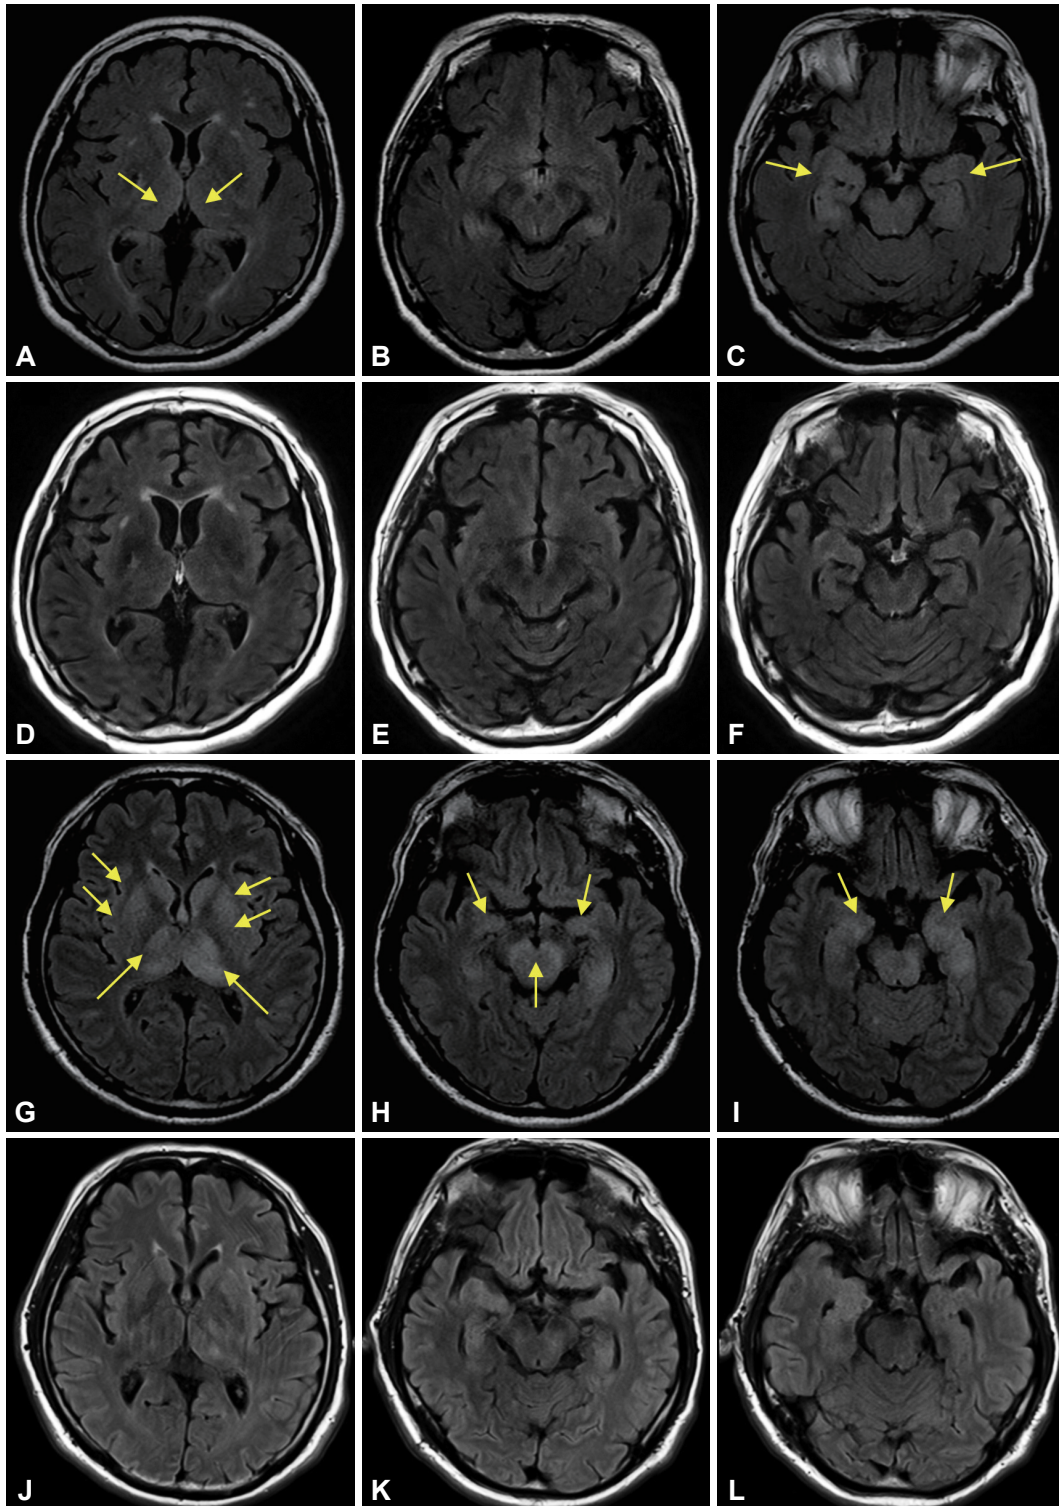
Initial and follow-up magnetic resonance imaging (MRI) studies were performed in two patients (Patient 2 and 5) at the initial hospital admission (A, B, C, G, H, and I) and at 2 weeks after symptom onset (D, E, F, J, K, and L), respectively. Relatively symmetric high signal intensities (yellow arrows) in the bilateral medial thalamus and medial temporal lobes (A, B, and C) of Patient 2 and in the bilateral basal ganglia, thalamus, hippocampus, medial temporal lobe, and midbrain (G, H, and I) of Patient 5 were evident in T2-weighted fluid-attenuated inversion recovery (FLAIR) images. Lesions in the initial MRI were decreased on the follow-up FLAIR images (D, E, F, J, K, and L).
